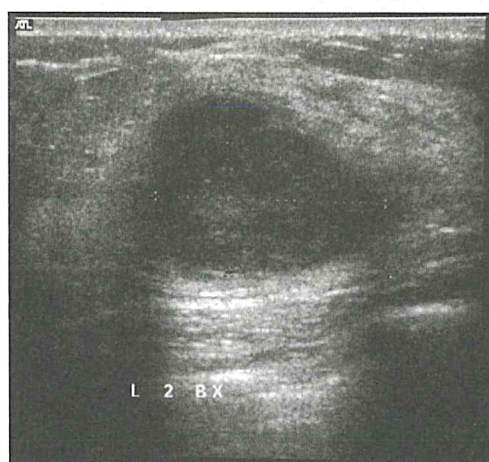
The corresponding sonogram reveals a partially ill-defined lobular mass with hypoechogenicity and internal cystic spaces.
